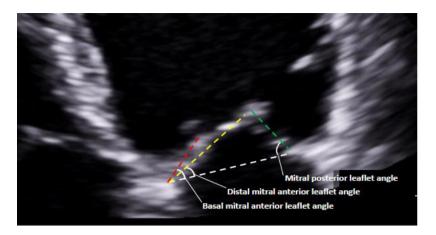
Example of mitral valve angle quantification on echocardiography.
